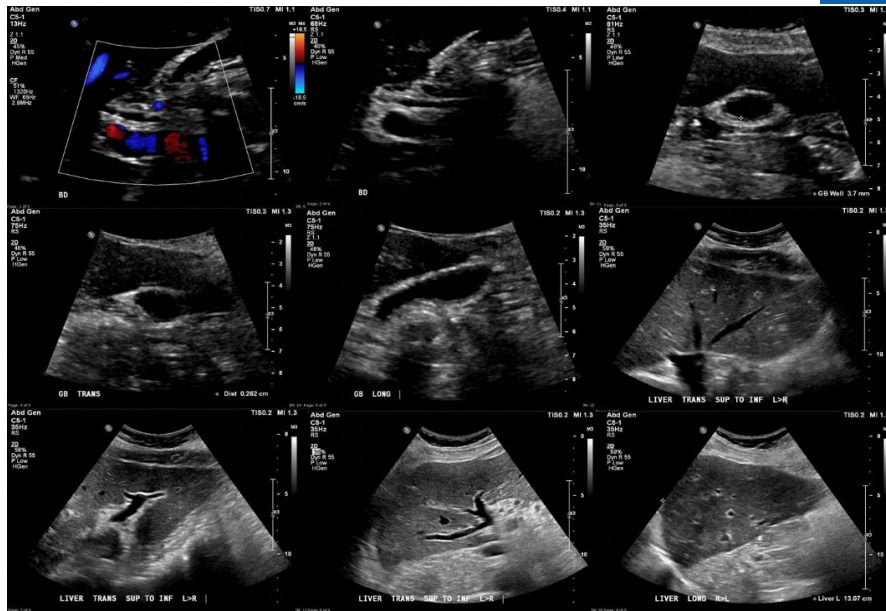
Patients normal ultrasound of the liver, gallbladder and bile duct.
